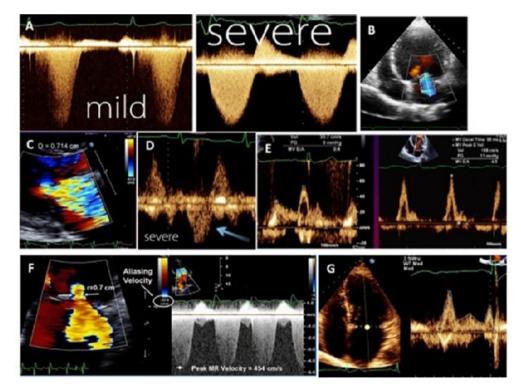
Methods used for MR quantification. Continuous Doppler tracing showing dense signal with severe MR and faint with mild MR (A), tracing of MR jet area (B), width of vena contracta (C), reversal of pulmonary venous flow (D), dominant E-wave of mitral inflow in severe MR (E), calculation of MR using PISA method (F), and volumetric measurement of stroke volume across the MV (G) [21]
